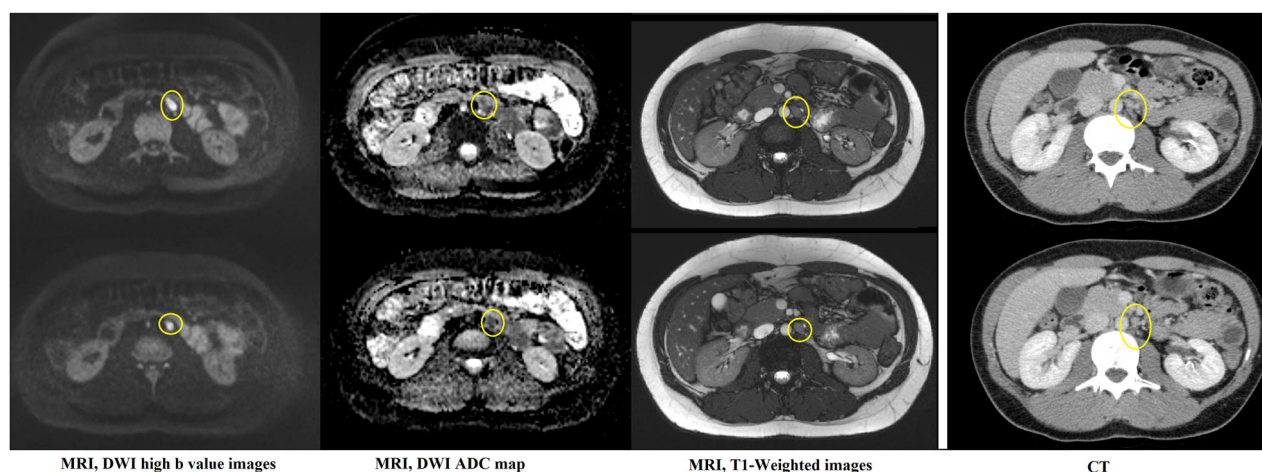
A 27-year-old man treated for a stage III SGCT pT1 with left radical orchidectomy and chemotherapy. Follow-up imaging 2 years later shows a round retroperitoneal LN of 1 cm. The LN was overlooked on the CT but detected on MRI, mainly because of the marked restricted diffusion (yellow circles)
